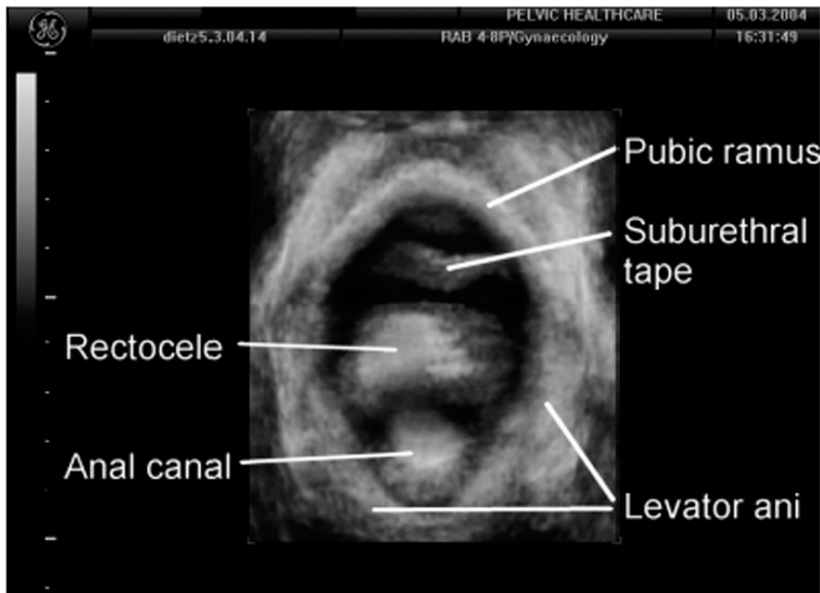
A translabial, three-dimensional ultrasound image (7–4-MHz volume transducer) of the pelvic floor showing a rectocele viewed from caudally, i.e. as if the patient was examined in lithotomy. The space of the levator hiatus is largely taken up by a third degree rectocele. There is also a suburethral tape anteriorly.
